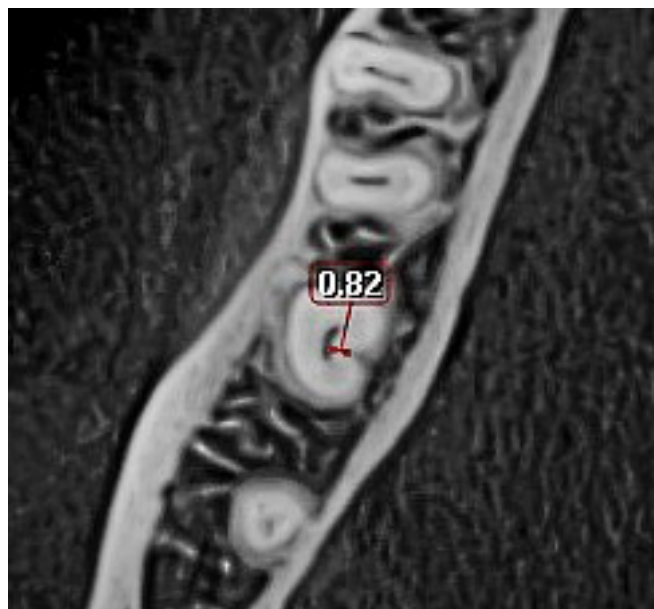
Measurement of thinnest dentin thickness on CBCT
